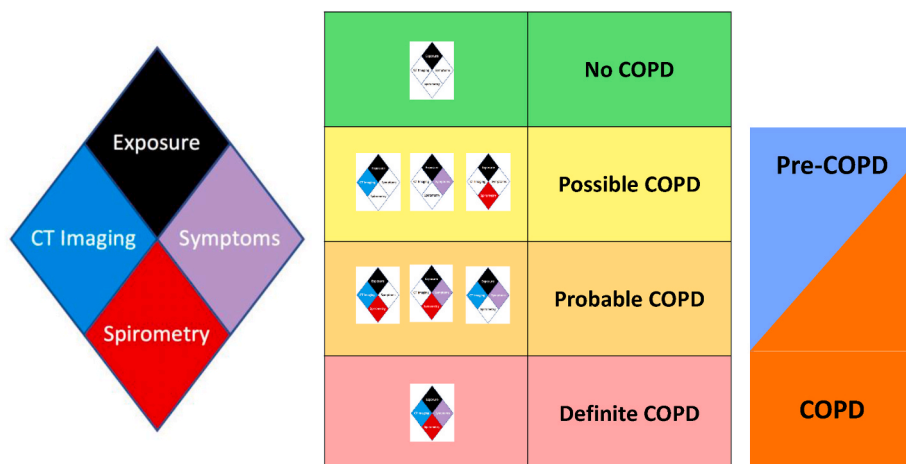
The relationship between exposures, symptoms, imaging findings, and spirometry in the definition of COPD as defined by COPDGene 2019 [2]. In this definition exposure is at least 10 pack years of smoking, CT Imaging is evidence of emphysema or airway thickening, symptoms are either dyspnea or chronic bronchitis, and spirometry is either obstructive or restrictive impairment. Patients in the possible or probable COPD categories may be categorized as either COPD or Pre-COPD. With permission from the American Journal of Physiology, Lung Cellular and Molecular Physiology [51].
